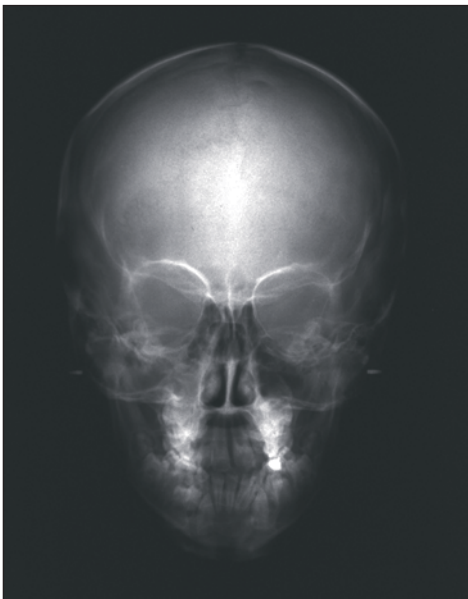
The posteroanterior cephalometric radiography did not reveal any significant asymmetry of any craniofacial structure.
